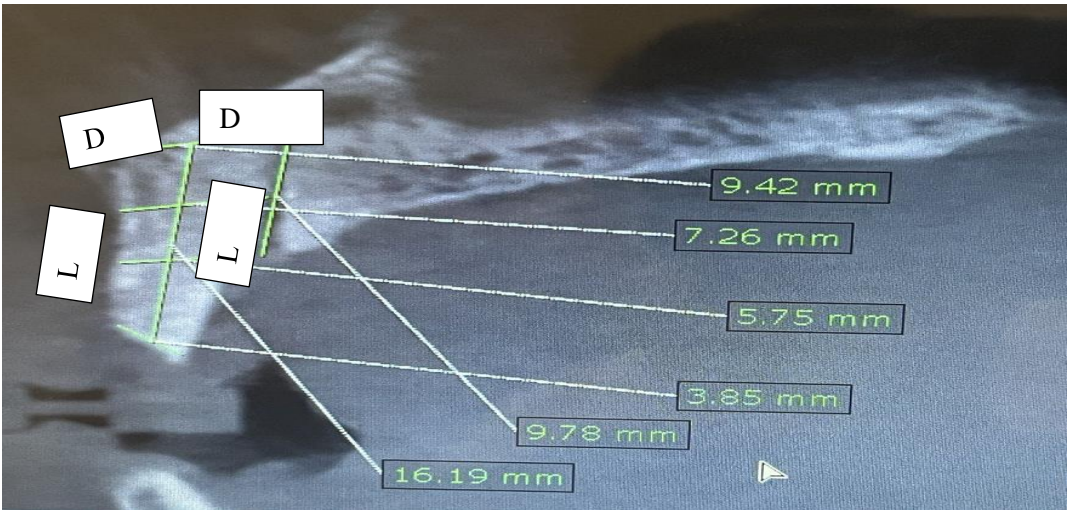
Linear analysis of Premaxilla outline in sagittal view of CBCT
